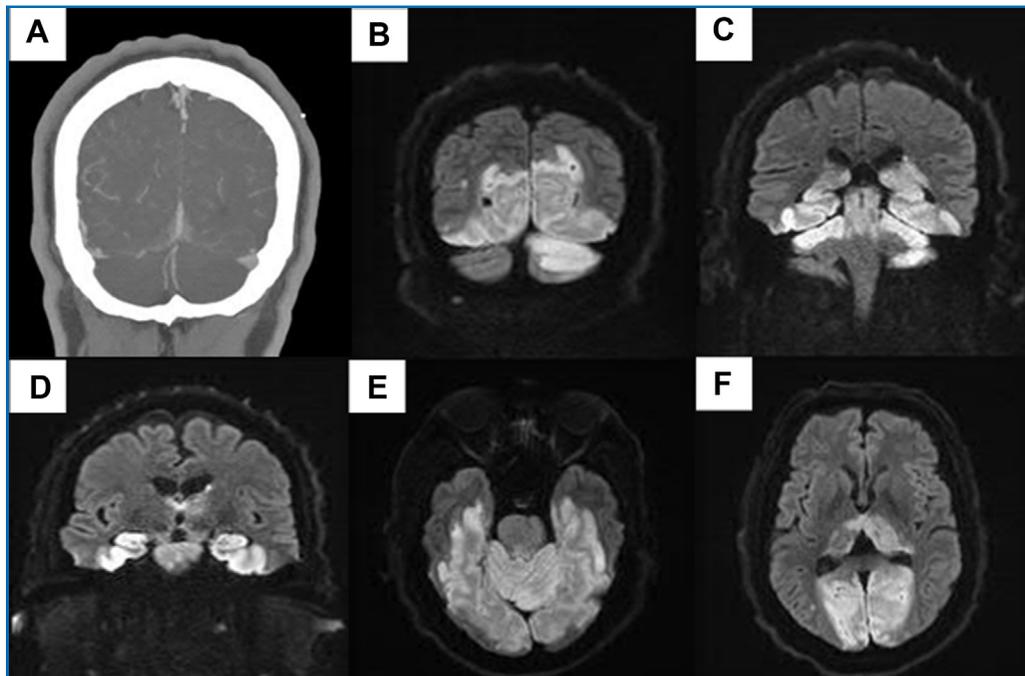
A, Representative coronal image of the initial computed tomographic angiogram of the head and neck, which revealed proximal-mid basilar artery thrombosis with no evidence of a vertebral dissection. B-F, Magnetic resonance imaging diffusion-weighted sequences show extensive acute infarcts bilaterally involving the thalami, midbrain, pons, inferior and medial temporal lobes, and occipital lobes consistent with widespread infarcts involving the posterior circulation. There was minimal inferior parietal involvement, which was thought to be within the posterior cerebral artery territory. The medulla and inferior cerebellum were spared. This distribution is concordant with the basilar thrombosis seen on angiography. Although sulcal effacement was present, there was no development of significant mass effect, obstructive hydrocephalus, or evidence of hemorrhagic transformation.
